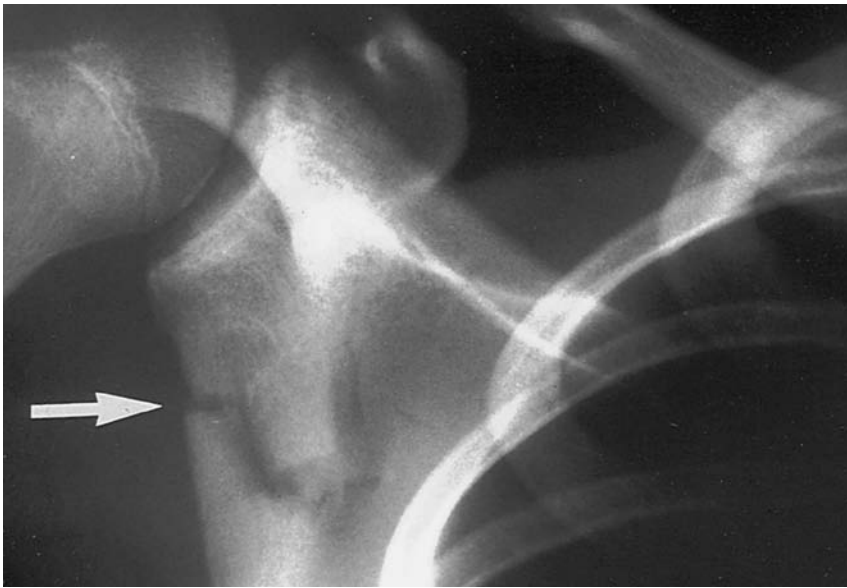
Radiograph of a 13-year-old boy who sustained an isolated right scapular fracture as the result of a skateboarding accident (*arrow*).
